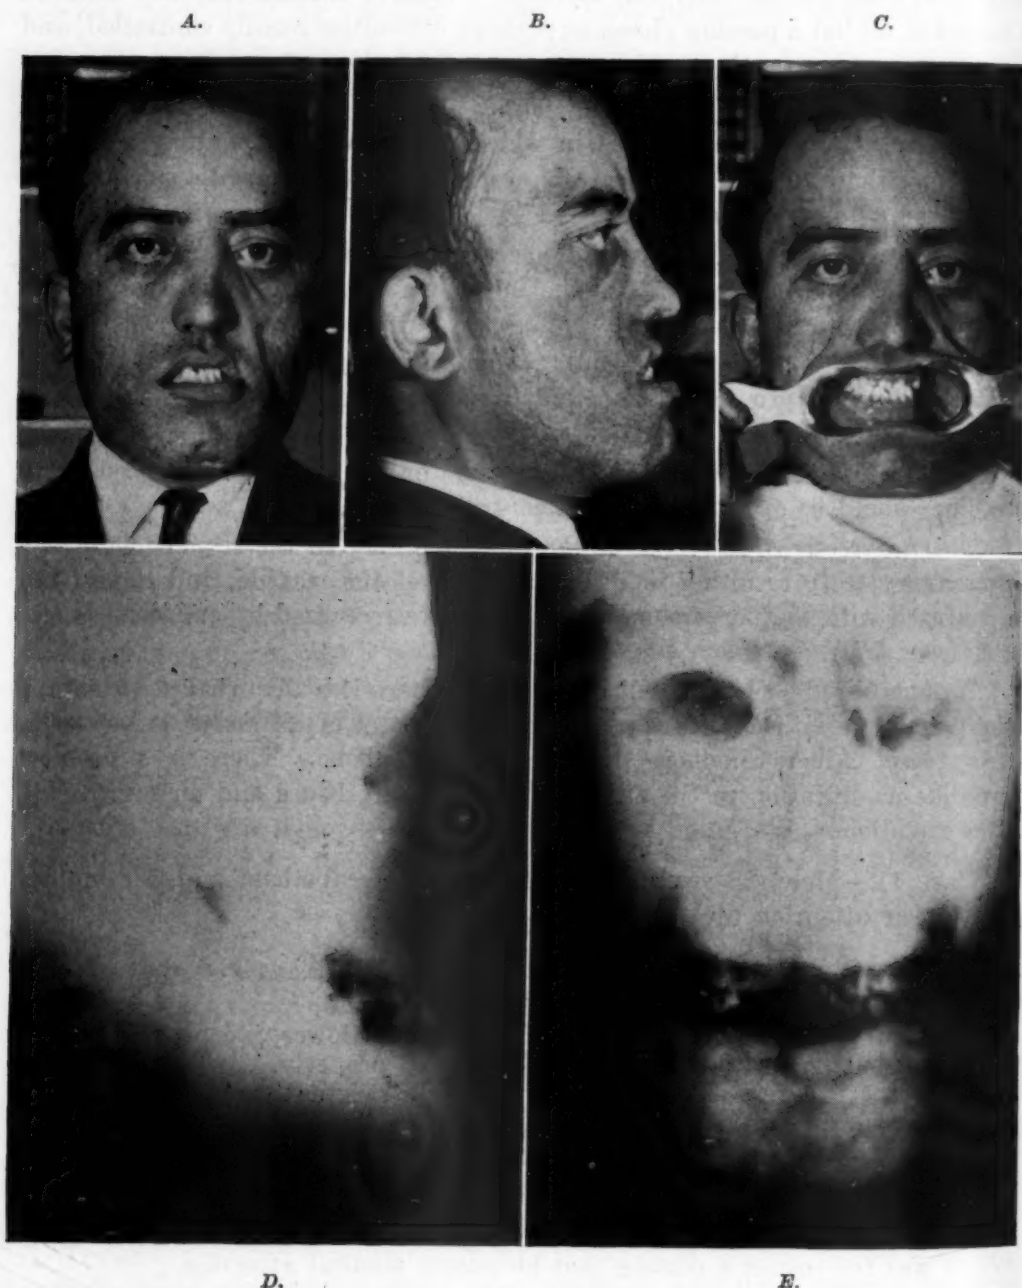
A, Albers-Schönberg disease, marble bone, or osteopetrosis. Front view, note massive facial structures. B, Profile view indicating extremely prognathous mandible. C, Occlusal view. Mandibular anteriors close 1.5 cm. in advance of maxillary incisors. D, Profile roentgenogram. X-ray penetrates dense bone with difficulty. E, Anteroposterior view also impenetrable to x-rays. F, Full-mouth x-ray series required an unusually long exposure. G, Hand shows peculiarly barrel-shaped metacarpal and phalanges.
